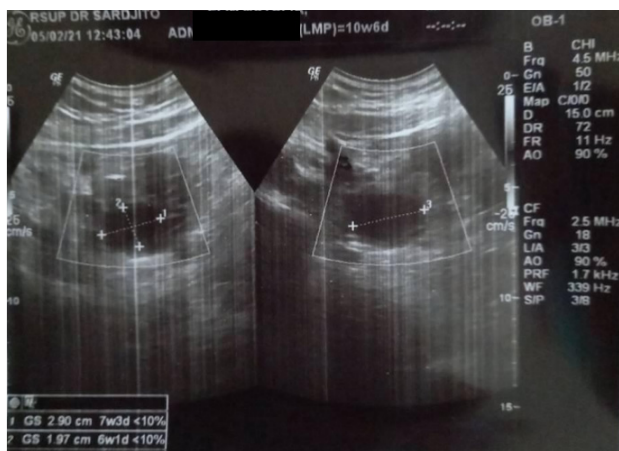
The Transabdominal Ultrasound Showed that the Gestational Sac was Seen with the Size Of 3.34 X 2.90 X 1.97 cm in Diameter Visualized in the Lower Uterine Segment, but with Fetal Pole was not Seen
